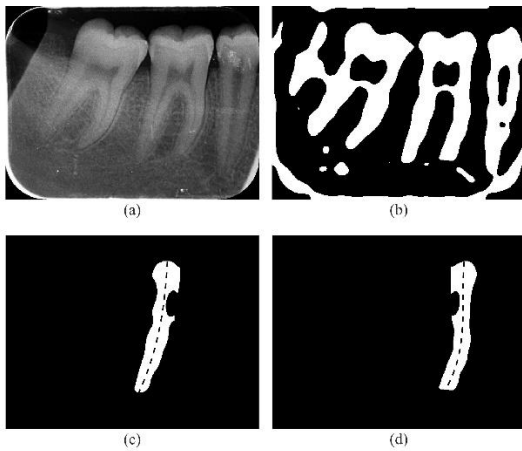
Midline detection for two roots of a double-rooted tooth: (a) the original radiograph; (b) the binarized radiograph; (c) the selected left part of the tooth in the middle; (d) the selected right part of the tooth in the middle. The dashed black lines are the midlines.
